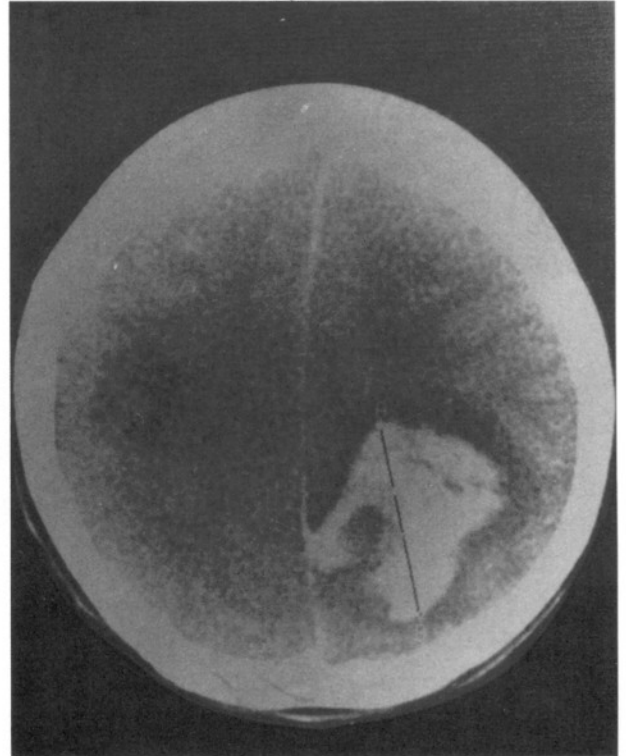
CT photo showing a large right occipital hematoma.
